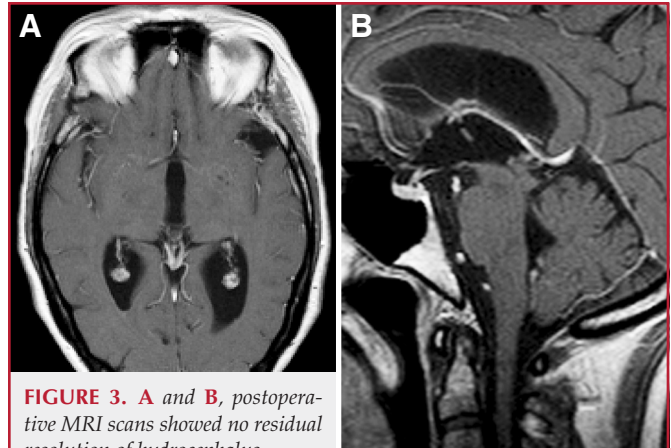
A and B, postoperative MRI scans showed no residual resolution of hydrocephalus.
